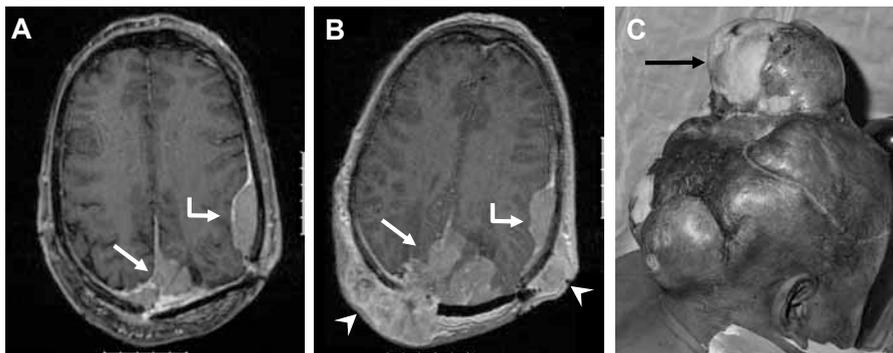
Example of patient with large, cranial meningioma. Patient already had undergone surgery 4 times and had had external beam radiotherapy before ^{177}Lu -octreotate. (A) MR image 1 wk after first cycle of ^{177}Lu -octreotate shows meningioma (arrow, curved arrow) with some extracranial involvement. (B) MR image 1 mo after final dose of ^{177}Lu -octreotate. Intracranial part of meningioma has increased (arrows). Extracranial, exophytic parts have increased as well (arrowheads). (C) Photograph of patient 18 mo after last dose of ^{177}Lu -octreotate (view from right, posterooblique). Patient had undergone surgery and had had external beam radiotherapy again and had just finished 6 cycles of cisplatin without therapeutic effect. Arrow indicates very large, extracranial part of meningioma with ulcerated skin.
